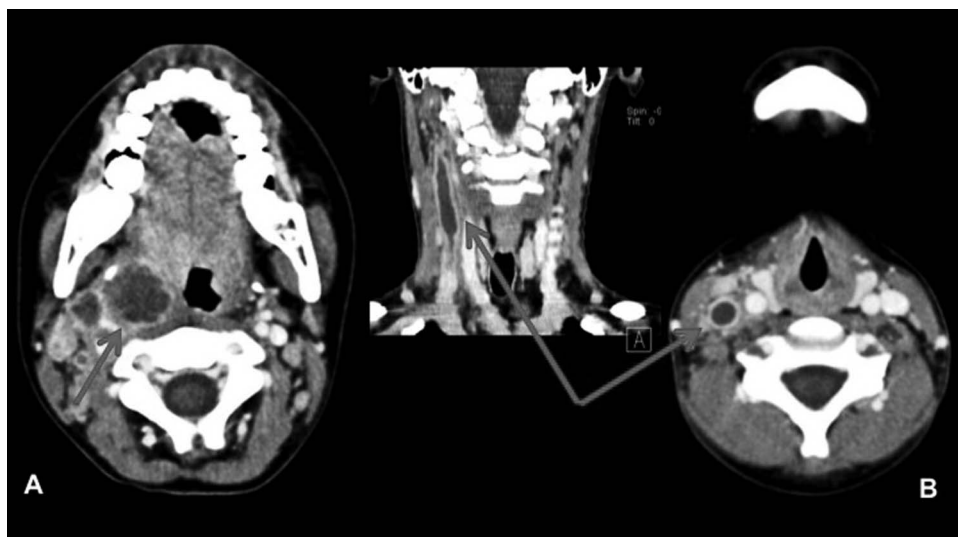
Neck CT scan with parapharyngeal abscess (A) and thrombosis of right internal jugular vein (B).
